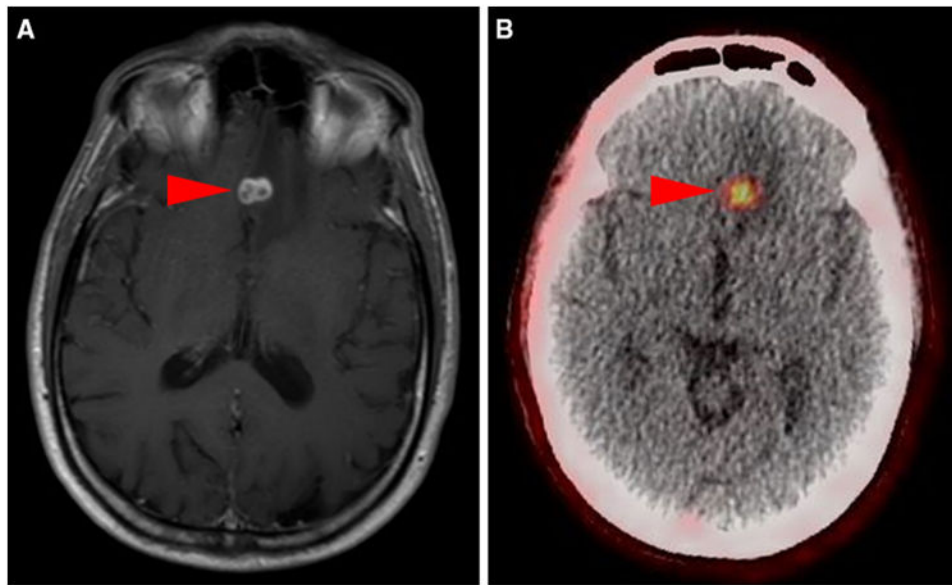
Axial contrast-enhanced T1-weighted MRI of the brain (a) and ^{18}F -DCFPyL PET/CT (b) from patient #2 demonstrating an intensely ^{18}F -DCFPyL-avid (SUV_{max} 3.9) brain lesion in the left frontal lobe (*arrowheads*)
